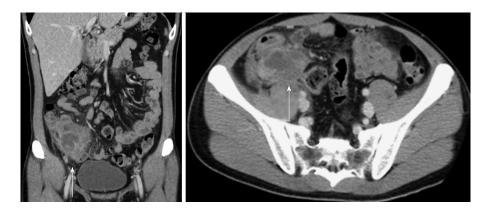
Representative computed tomography images of appendiceal diverticulitis. An oblique coronal reformation of a contrast-enhanced CT (5-mm thick) (arrow) showing localized periappendiceal abscess. However, the appendix itself is not visualized clearly.
